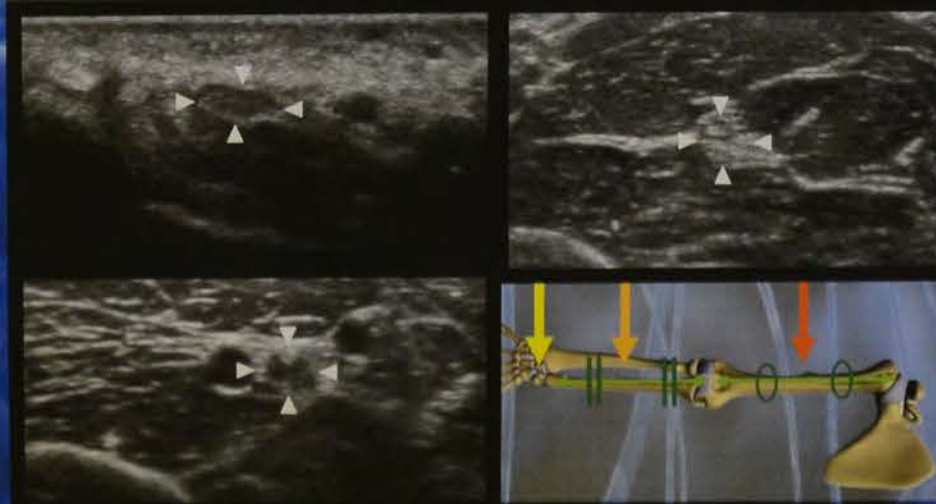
Transverse sonograms of the nerve at the each level. Arrow heads show the median nerve.
